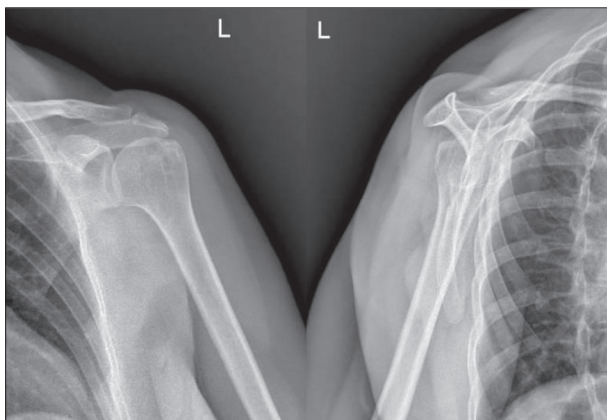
Anterior-posterior X-ray of the left shoulder and Y radiography of the scapula – status after closed reduction, the shoulder joint is congruent [source: PACS, Bežanijska Kosa University Hospital Medical Center]
